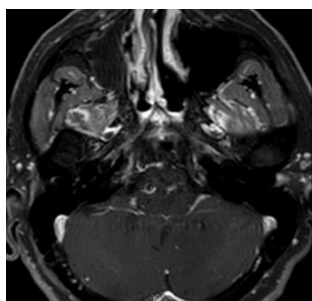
d. 5 years after treatment T1 axial MRI scan
